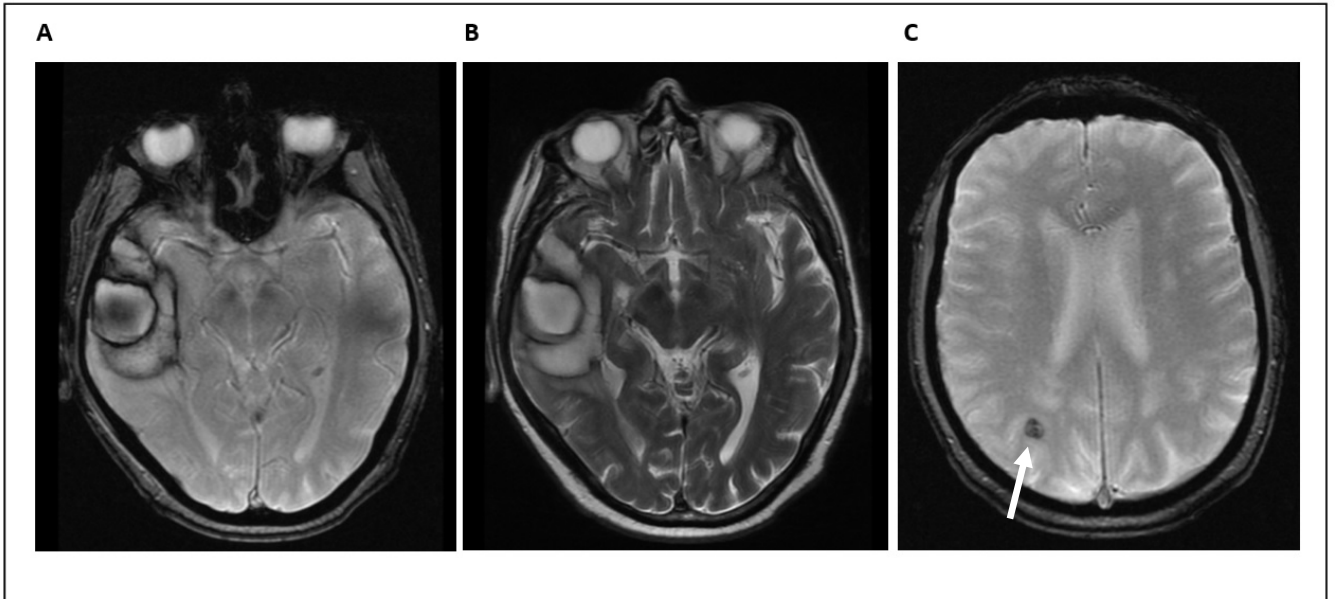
MRI head performed one month following intracerebral hemorrhage. A, Gradient echo and B, T2-weighted MRI showing evolution of the hemorrhage, with low intensity peripherally, indicating hemosiderin formation. C, Gradient echo demonstrating an additional 8mm focal right parietal hemorrhage (arrow).
